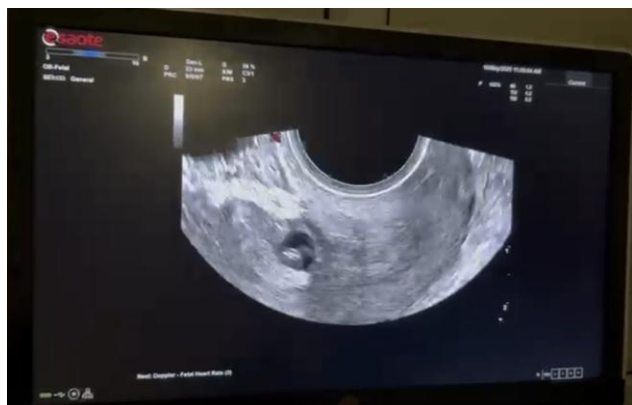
Transvaginal ultrasonography of live CSP.
